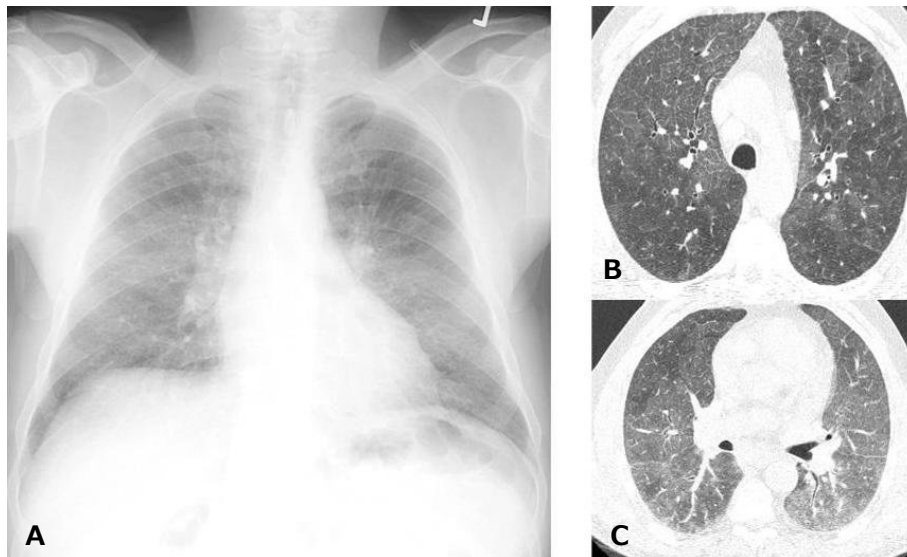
Chest X-ray (A) and high resolution CT-scan (B/C) of a patient suffering from diffuse alveolar hemorrhage (DAH) showing widespread ground-glass attenuation.
